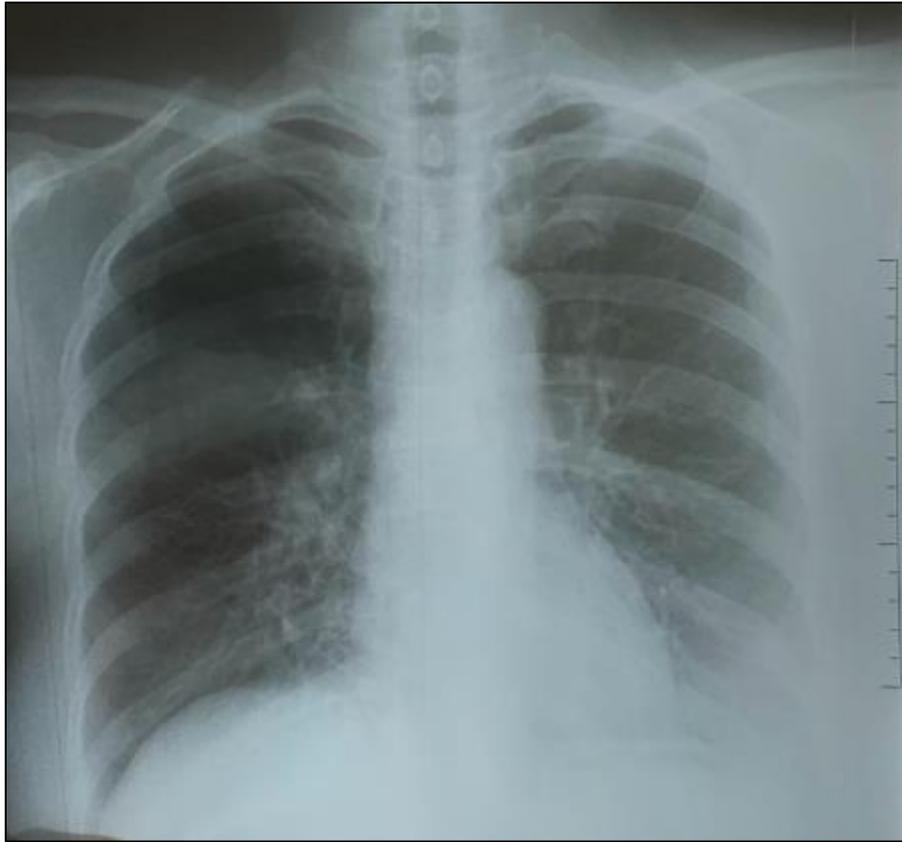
Chest X-ray showing a diffuse bilateral interstitial syndrome with right hilar lymphadenopathy
